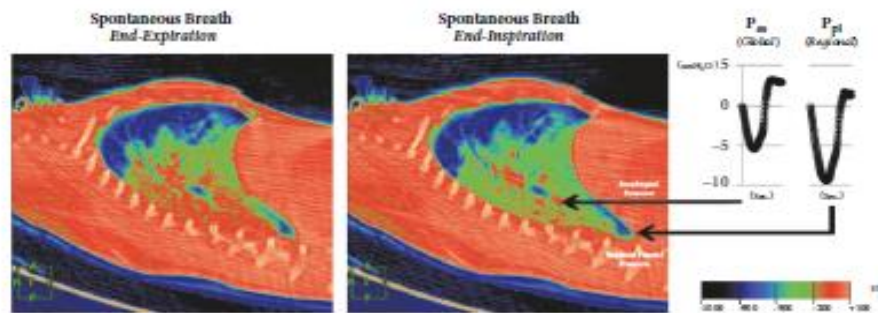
Dynamic CT scan in end-expiration (left panel) demonstrates that the aerated lung (blue) is nondependent, while the dependent lung is densely atelectatic (red). At end-inspiration during a spontaneous breath (mid panel), there is little change in the nondependent aerated lung (blue); the dependent lung, previously densely atelectatic (red) is now partially aerated (green/red). The inspiratory pleural pressure traces (right panel), measured at the arrow tips, show the negative deflections (“swings”) in regional Ppl and global Pes during inspiration. However, the “swing” in regional Ppl is greater (x2) than the “swing” in Pes, indicating that diaphragm contraction results in greater distending pressure applied to the regional lung near the diaphragm compared with the pressure transmitted to the remainder of the lung (i.e., Pes). Ppl: pleural pressure; Pes: esophageal pressure; HU: Hounsfield Units, with authors permission [15].
